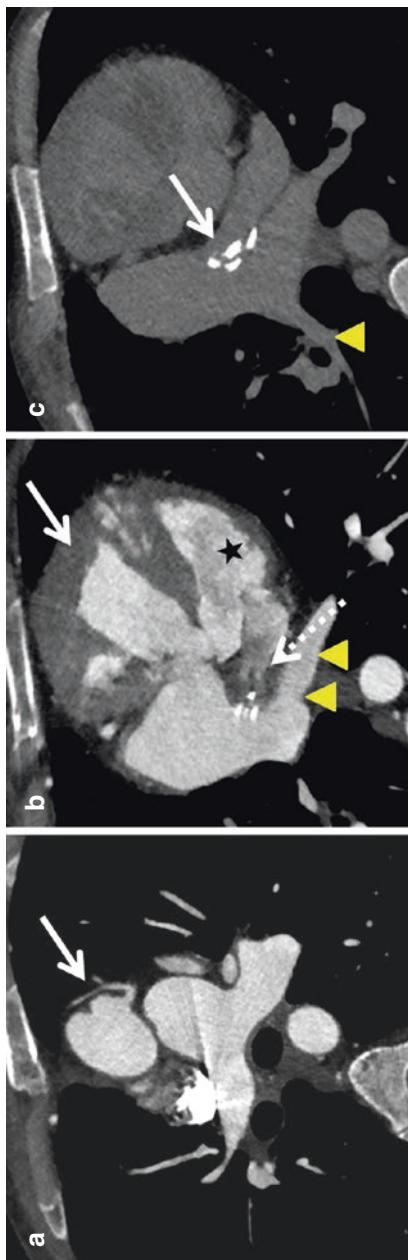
D-TGA. Axial CTA images show aorta (arrow in a) arising from morphologic right ventricle (arrow in b) and pulmonary artery arising from morphologic left ventricle (asterisk in b). The pulmonary veins (arrowheads in b and c) drain into the right atrium. The venous inflow is connected to left atrium via a baffle (dotted arrow in b, arrow in c) known as Mustard procedure. Delayed image were helpful in detecting baffle stenosis (arrow in c) in this case
